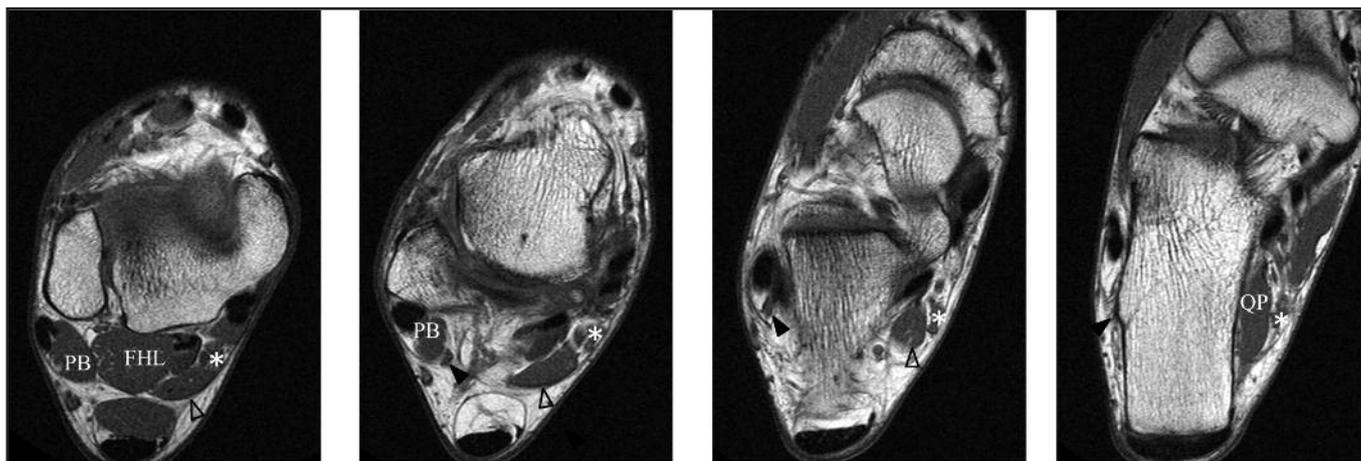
Sequential cranial-to-caudal axial T1-weighted images. The FDAL (open arrow head) courses posterior to the flexor hallucis longus (FHL), abuts the neurovascular bundle (*) proximally, runs deep to the deep aponeurosis and flexor retinaculum, and inserts onto the quadratus plantae (QP). Meanwhile the fleshy accessory peroneus quartus muscle (arrow head) courses posterior to the peroneus longus and brevis (PB) tendons and inserts onto the retrotrochlear eminence of the calcaneus.
